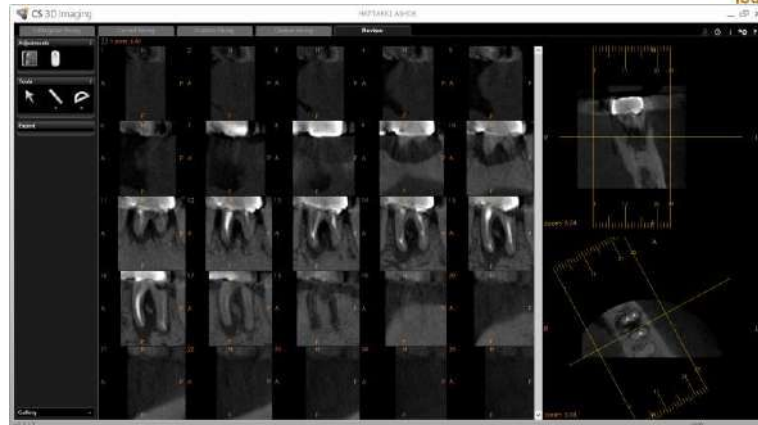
3.1. Diagnostic radiograph Fig 3.2 CBCT image showing axial and sagittal sections and fracture on mesial root Courtesy Dr. Nair
